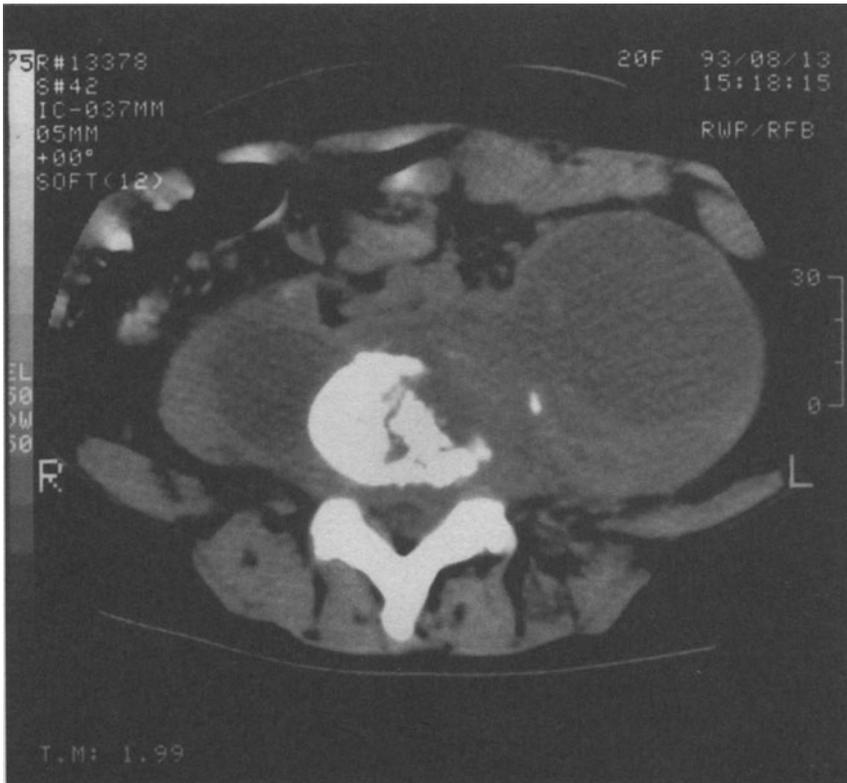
CT scan of 19-year-old Asian girl with left inguinal swelling. Erosion of lumbar vertebra with bilateral psoas abscesses (L>R).
